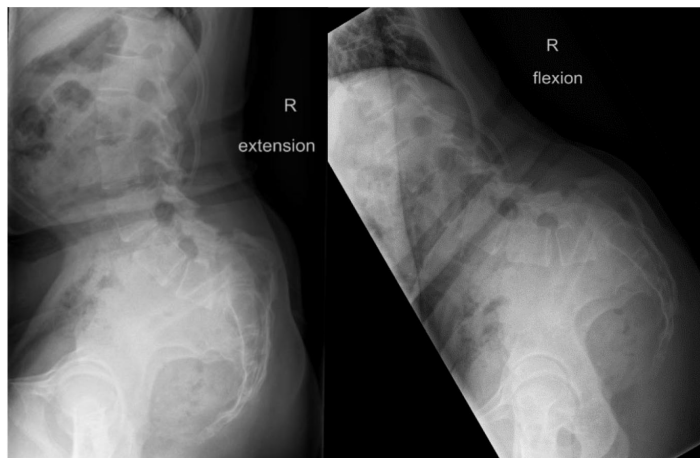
Pre-operative sagittal flexion-extension radiographs.
